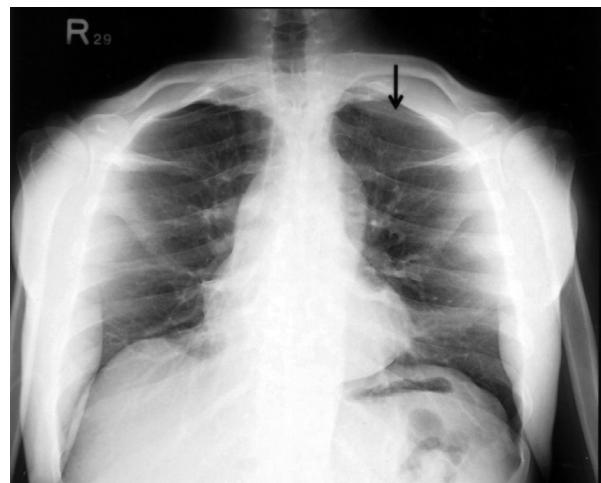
Lordotic view of the chest radiograph showed increased soft tissue density at the left apical lung region with bony destruction of the left 1st rib (arrow).
